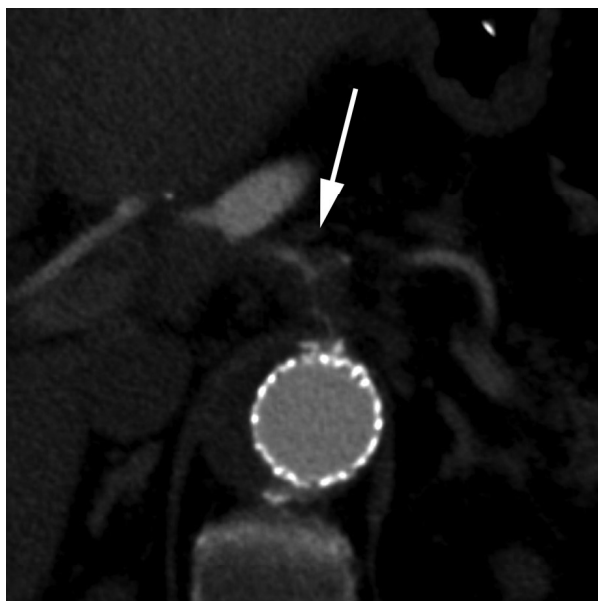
Double-oblique multiplanar reconstruction (MPR) of computed tomographic angiography (CTA) after thoracic endovascular aortic repair (TEVAR) reveals a type II endoleak (ELII) (*arrow*) originating from the celiac trunk.
